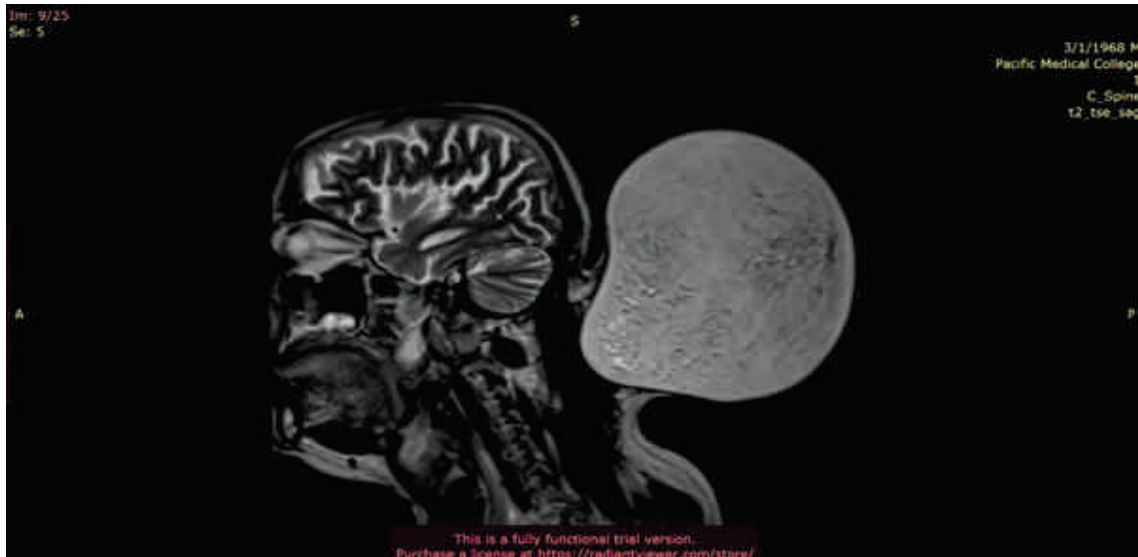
T2 weighted MRI image showing giant Fibrolipoma at neck without any deeper connections
